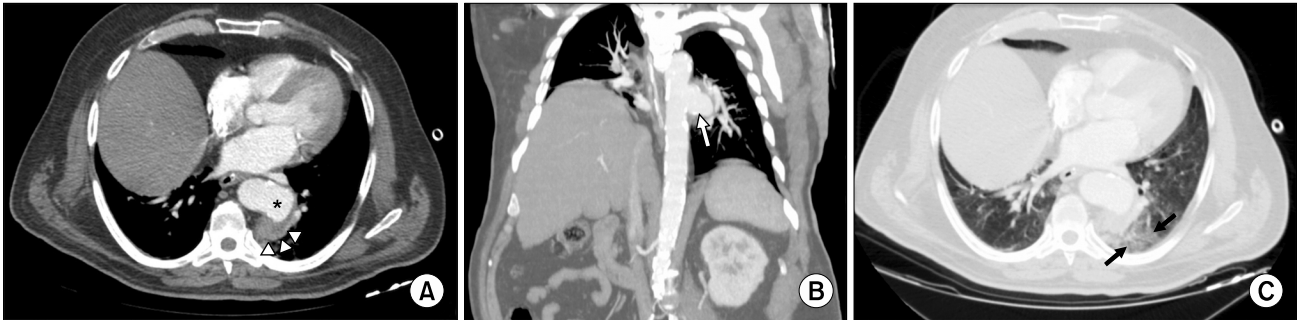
Contrast-enhanced multidetector computed tomography showing (A) a saccular aneurysm (asterisk) and perianeurysmal atelectasis (arrowheads), (B) favorable position of the aneurysm in reformatted coronal oblique multiplanar reconstruction (arrow), and (C) the presence of ground-glass opacities (arrows).
